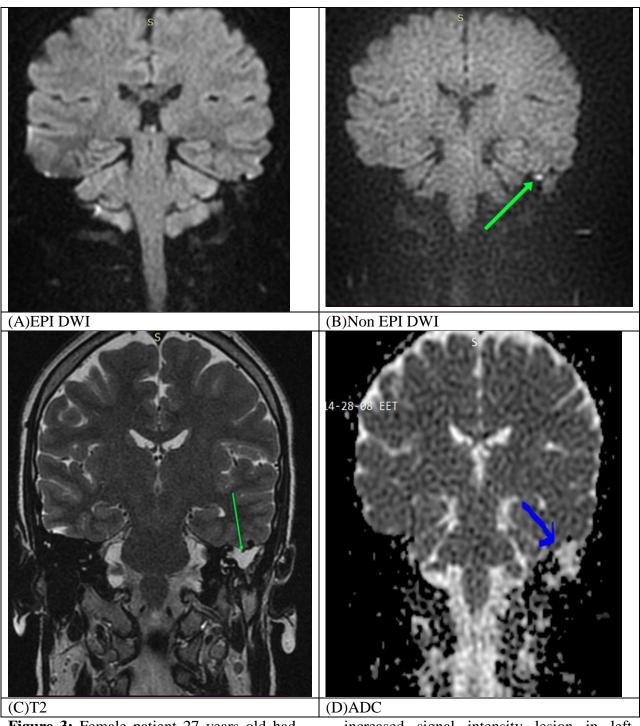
Female patient 27 years old had cholesteatoma (A): EPI DWI: lesion cannot properly visualized (no diffusion restriction). (B): NON-EPI DWI: there is well defined lesion measuring 3x0.5mm of increased signal intensity in Non-EPI DWI and low signal intensity in ADC in left middle ear, (C): MRI:T2: abnormal
